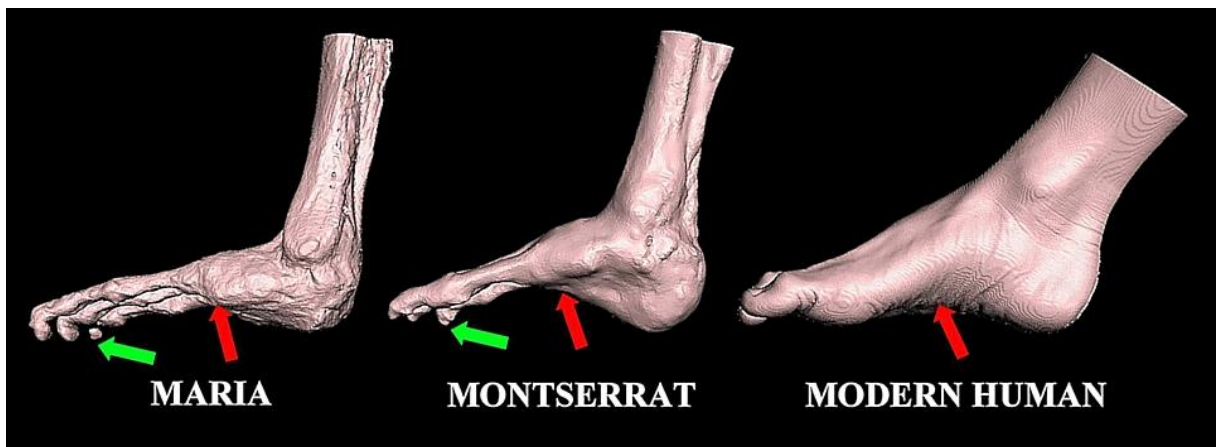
Comparison of 3D CT of right foot of Maria (*left*), Montserrat (*middle*) and modern human (*right*). Note the difference in plantar arches (*red arrows*) and the length of digits. Claw-like deformities in the most distal segments of digits (*green arrows*) in Maria and Montserrat were noted, more pronounced in Maria.
